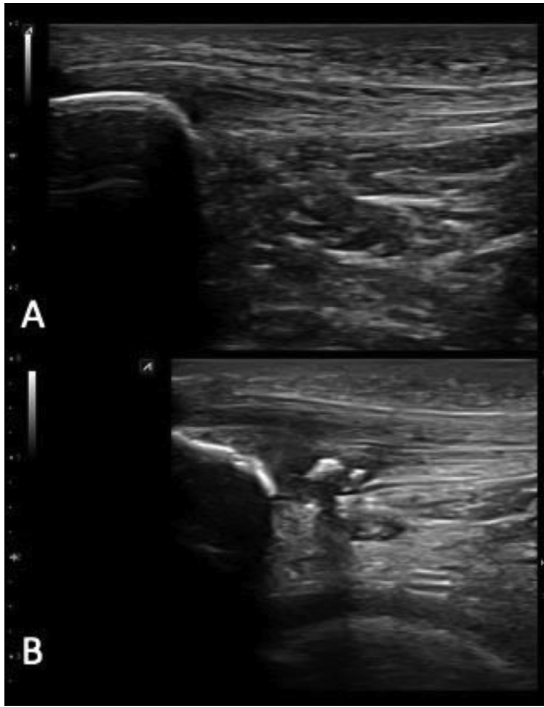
Ultrasound imaging in a longitudinal view of a healthy tendon (A) and a intrasubstance calcification tendon (B).
